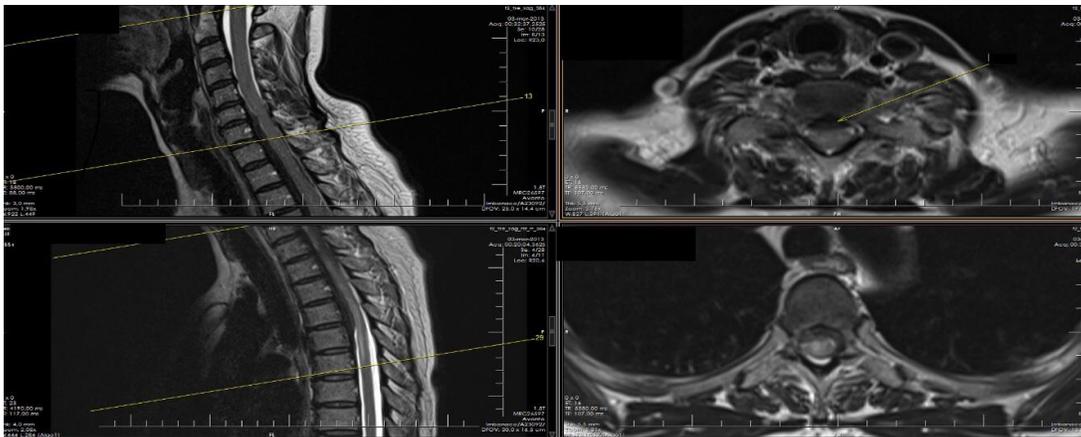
Initial MRI (T2 weighted image) of Cervico-thoracic spine with extradural anterior mass with low signal intensity.
